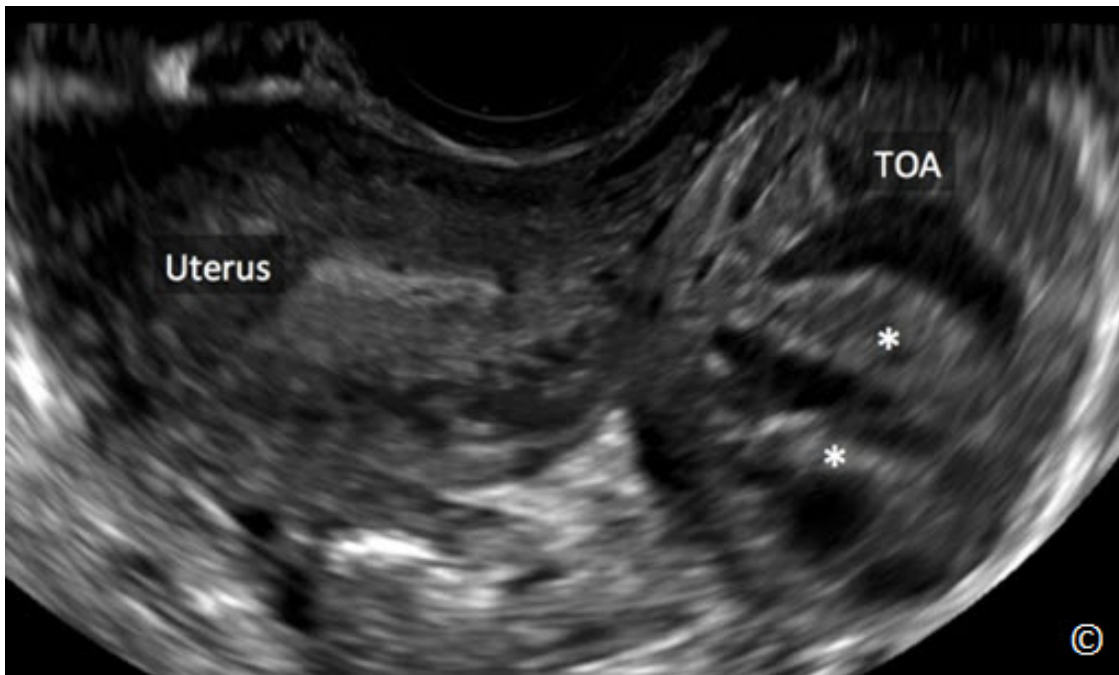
Transvaginal ultrasound of a tubo-ovarian abscess (TOA). Note the ovoid shape of the TOA, with thickened walls and septations (asterisks). The uterus (labeled) is noted adjacent to the TOA.
